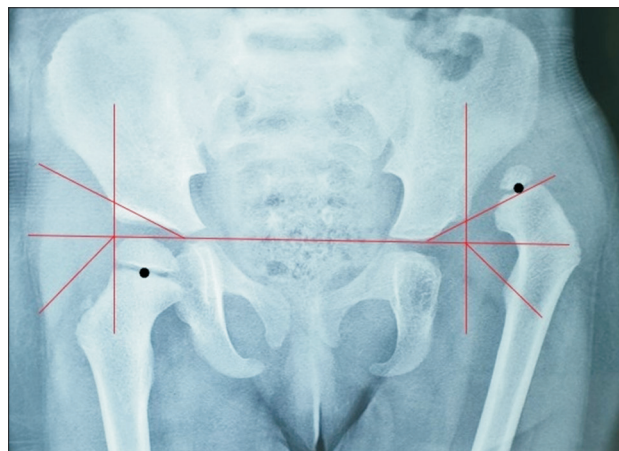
Case example of a pelvic radiograph of another infant with developmental dysplasia of the hip. The right hip was classified as grade 2B according to the upgraded form of the International Hip Dysplasia Institute classification where the A-point is above the A-line (black dot, H-point).
